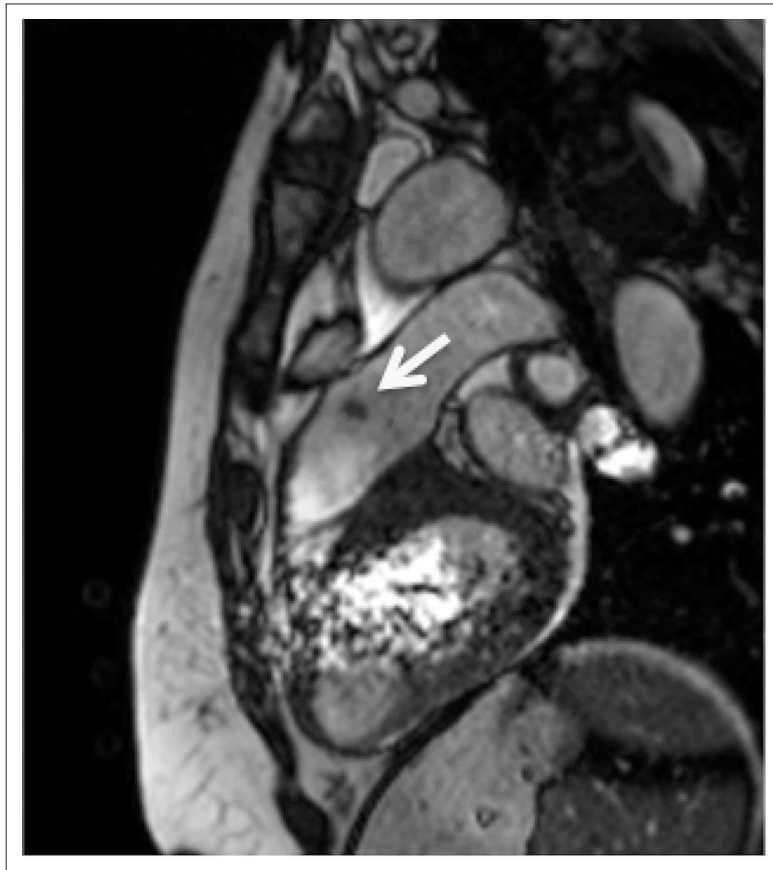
Pulmonary fibroelastoma on cardiac MRI. The image demonstrates a well-circumscribed low-density pulmonary valve mass in a T2-contrast-enhanced weighted image.
